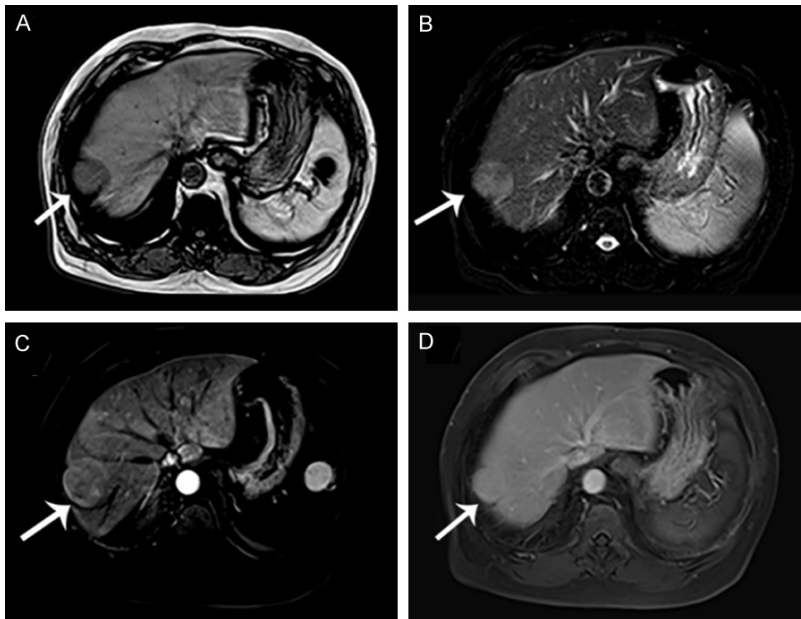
MR imaging of the liver. The entity presented low signal intensity on T1-weighted images (A), slightly higher on T2-weighted images (B). On dynamic contrast-enhanced imaging, the lesion manifested as “wash in” during the arterial phase (C) and “wash out” during the equilibrium phase (D).
